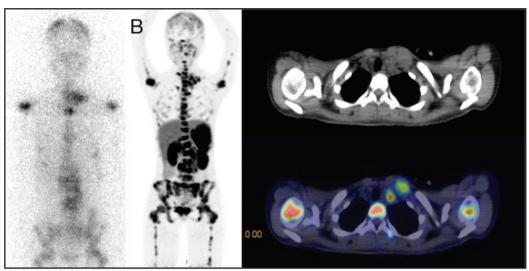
Comparative imaging evaluation of extent of disease of Patient 1 at initial diagnosis. Anterior planar image of staging ¹³¹I-MIBG scan (A), showing fewer lesions compared to maximal intensity projection image of ⁶⁸Ga-DOTATATE PET/CT (B); representative axial ⁶⁸Ga-DOTATATE PET/CT images of tracer-avid left supraclavicular adenopathy and bony lesions (C).
